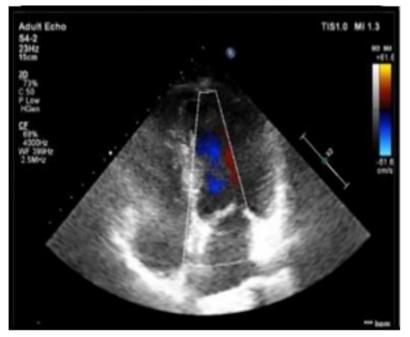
Bidimensional echocardiography, apical view, color doppler. In this patient with a left atrium of 38mm anteroposterior diameter there is no mitral regurgitation.
